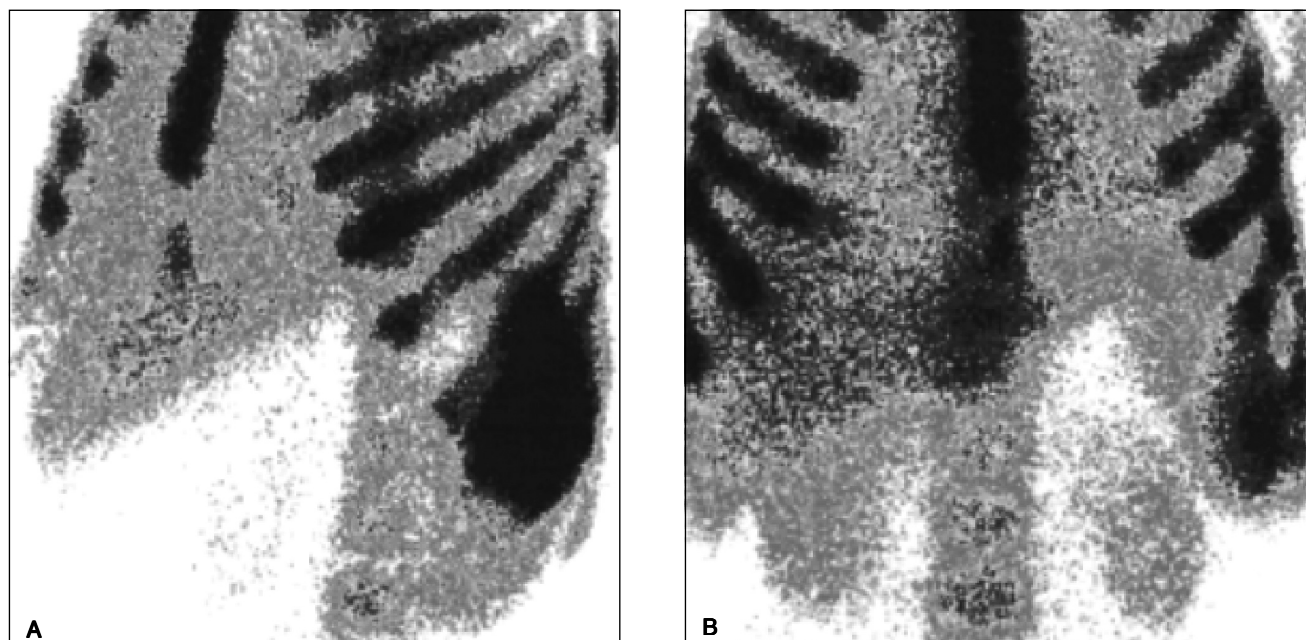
Positive result of two-dimensional scintigraphy with ^{99m}Tc-Anti-Granulocyte BW 250/183. The scintigraphy revealed accumulation of the tracer in cardiac area. A. Anterior view; B. LAO45 view.
